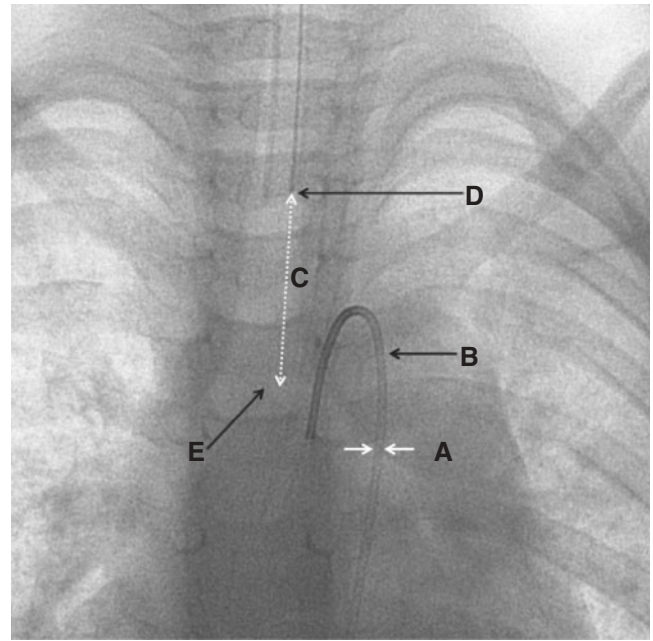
Calibration of the laboratory system was performed by electronically measuring the diameter (A) of a standard cardiac catheter on the radiograph (B) introduced into the pulmonary trunk, superior vena cava or ascending aorta. The distance (C) from the endpoint of the tube's radiopaque line (D) to the tracheal carina (E) was electronically measured and first corrected by the magnification factor and second corrected by subtraction of the clear, radiopaque free tracheal tube-tip portion, as provided by the manufacturer, to obtain the effective distance from the real tracheal tube tip to the carina.
